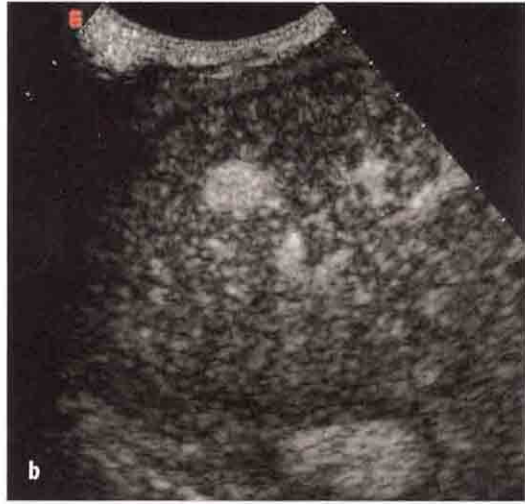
Focal nodular hyperplasia.* Baseline US shows a hypoechoic lesion on segment VIII (a). At contrast-enhanced US the lesion shows homogeneous enhancement in the arterial phase (b) with isoechoic appearance in the portal and delayed phases (c, d). At MR imaging, focal nodular hyperplasia appears slightly hypointense on the T1-weighted image (e), slightly hyperintense on the T2-weighted image (f), and hyperintense on the T1-weighted image acquired 1 hour after the injection of an hepatospecific contrast agent (g)
